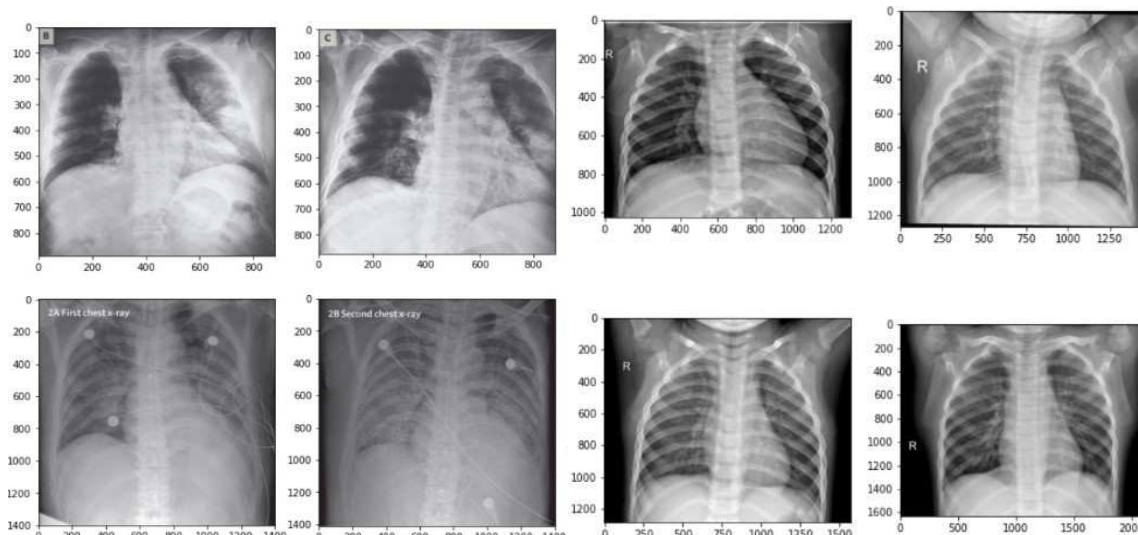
Sample images of Chest X-Rays of COVID-19 patients
